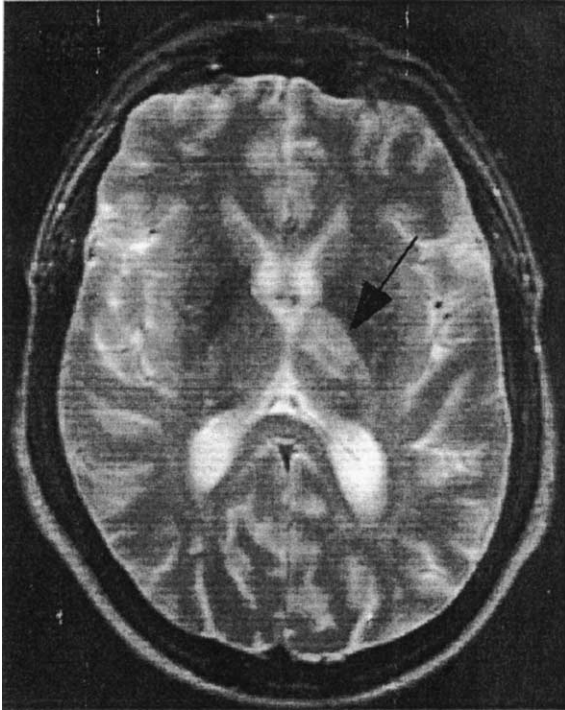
MRI showing an infarct of the left lateral thalamus.
